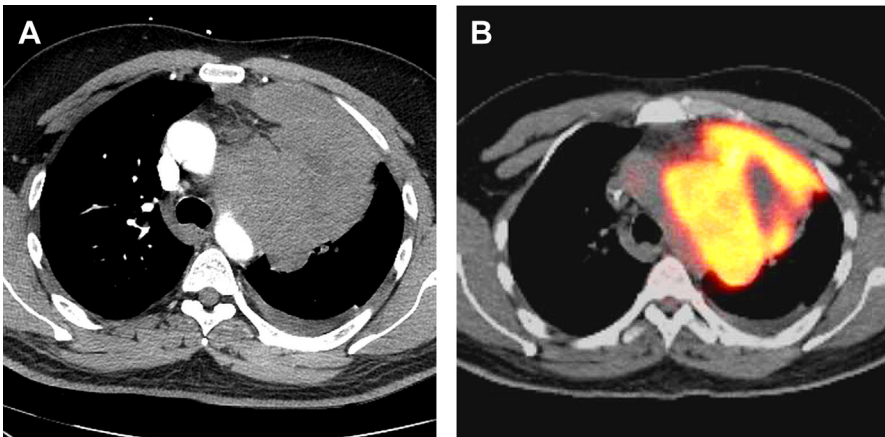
Diffuse large B-cell lymphoma. (A) Contrast-enhanced axial CT shows a heterogeneously enhancing mass involving the left prevascular mediastinum extending into the visceral compartment and compressing and/or invading adjacent vessels and the left lung. (B) Fused axial FDG PET/CT shows extensive FDG avidity in the mass with low uptake foci representing necrosis.
